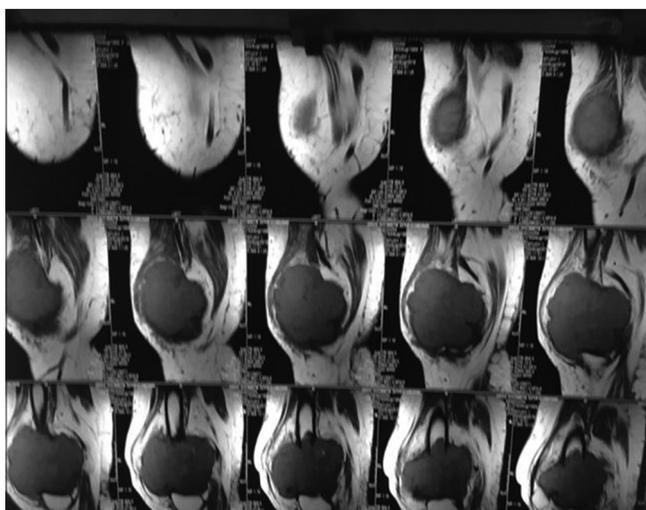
MRI left distal femur
